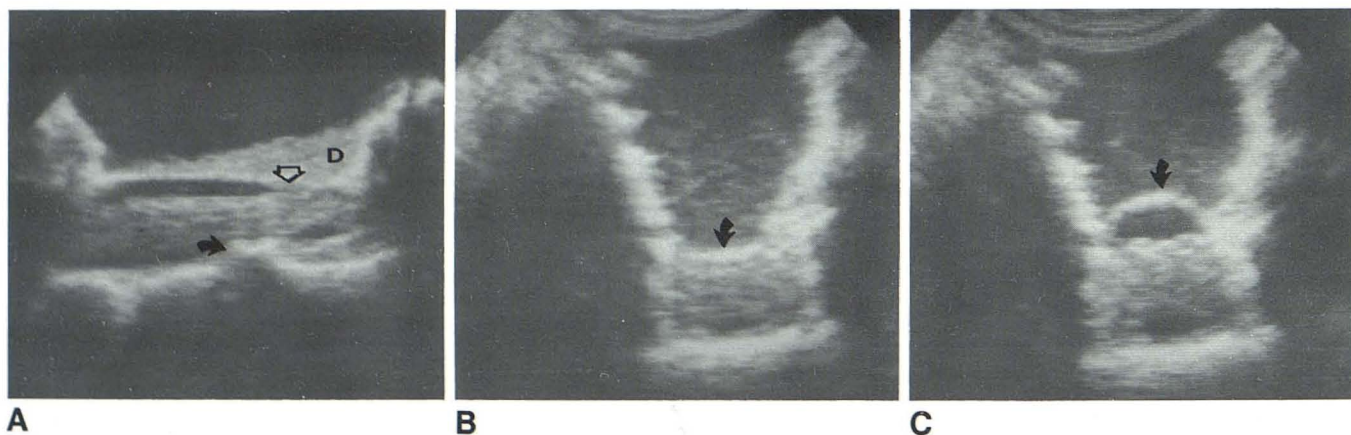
Case 2. A, Longitudinal intraoperative sonogram after lumbar laminectomy defines some narrowing of dural sheath posteriorly by thickening secondary to arachnoiditis (*open arrow*) and anteriorly by mildly protruding disk at L4–L5 with associated osteophytic spurring (*closed arrow*) causing acoustic shadow just inferior to disk. Some layering of debris (D) along the posterior surface of dural sac. Arachnoiditis suspected on CT by clumping of nerve roots
